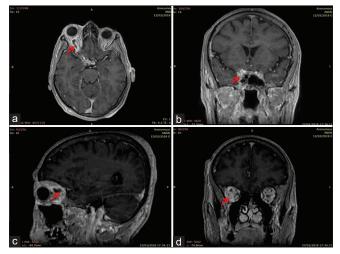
Brain MRI (T1 Gadolinium-enhanced): (a) axial section, (b and d), coronal section, (c) sagittal section: the arrow is pointing to right SOVT, (b) T1 coronal section: the arrow is pointing to the partial extension of thrombus into the right cavernous sinus
